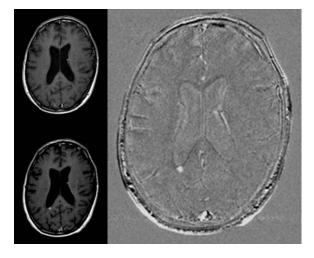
MR images and subtraction image of an enhancing plaque in a patient with MS
